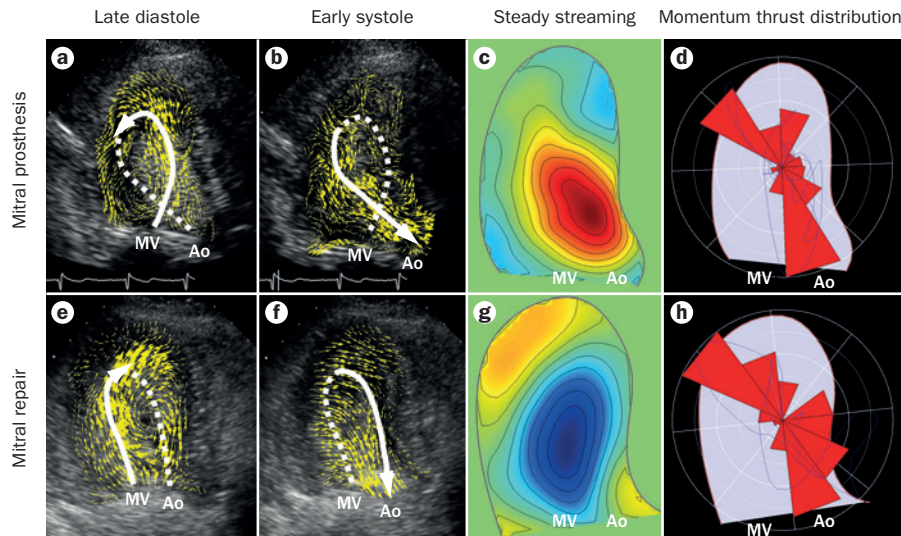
Echocardiographic recordings of postsurgical intraventricular flow. a–d | Implantation of a mechanical bileaflet mitral valve. The flow after valve prosthesis implantation shows the inversion of the vortex rotation that gives rise to higher turbulence and disturbed flow. e–h | Mitral valve repair, with normal flow rotation maintained. Velocity vectors are shown at late diastole (parts a and e) and early systole (parts b and f). The thick white line is used to sketch the mean path of blood flow during the heart beat (the continuous line represents blood-flow direction and the broken line refers to a mirror image of the subsequent or previous cardiac phase). Colour maps (parts c and g) show the steady-streaming pattern (the net-flow averaged over one heart beat) in terms of vortex rotation intensity from red (anticlockwise) to blue (clockwise). The polar histogram of the frequency and intensity of intraventricular forces is shown in parts d and h. In both mitral valve replacement and repair, intraventricular forces show a mild deviation from the longitudinal direction. Abbreviations: Ao, aorta; MV, mitral valve.
